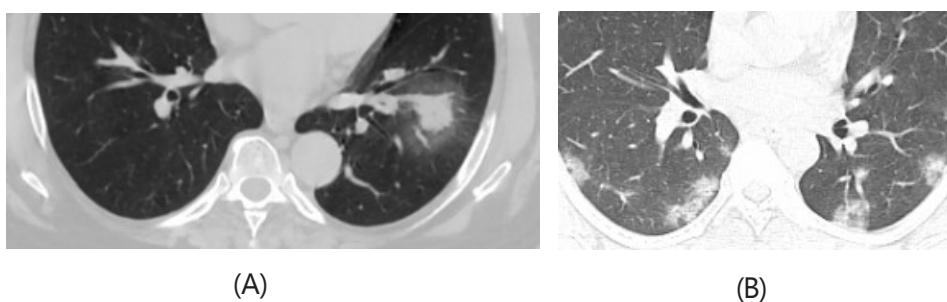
Atypical imaging manifestation of COVID -19 pneumonia: A - Axial CT section of 60 yrs old male patient shows central area of consolidation with surrounding ground glass opacity (Halo sign). B- Axial CT section of CT chest in 59 yrs old female patient shows reverse halo sign /Atoll sign (central ground glass opacity with surrounding consolidation)
